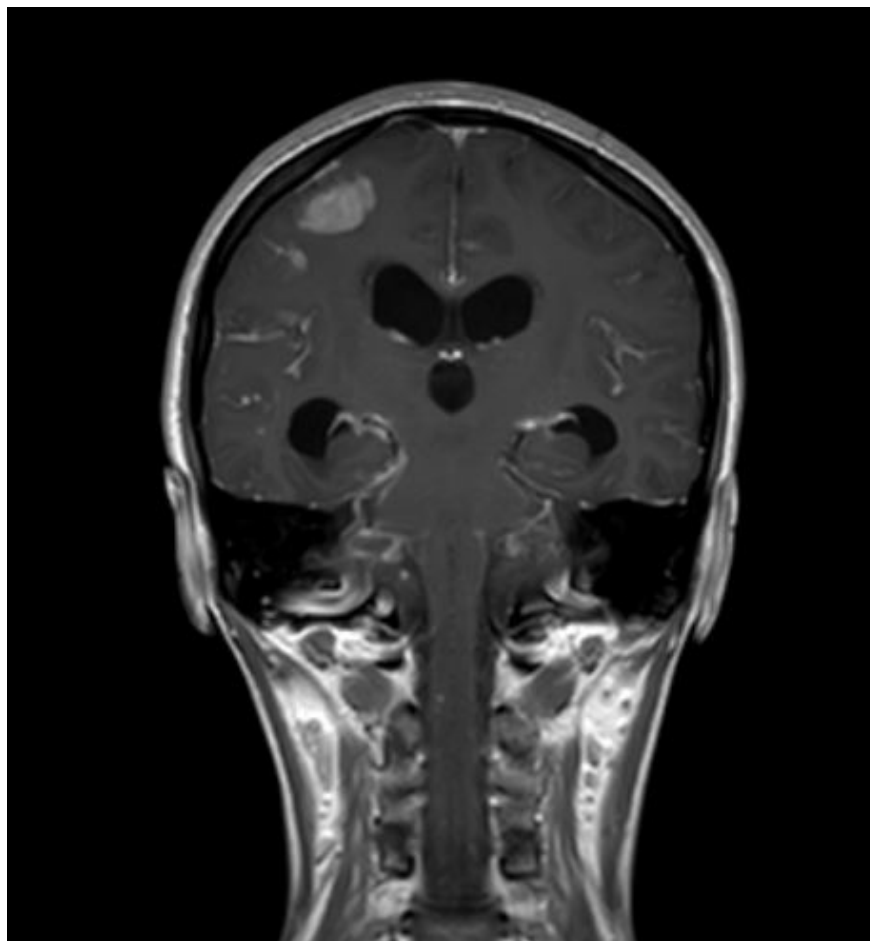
Post contrast MRI coronal section showing diffuse leptomeningeal enhancement in bilateral cerebral hemispheres with multiple enhancing nodular lesions in bilateral cerebral hemispheres, basal ganglia and brainstem.
